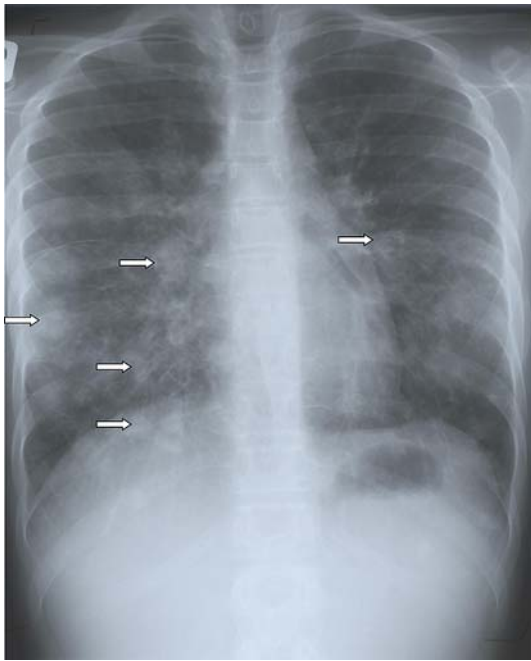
Chest X-ray of a patient with GBM. *Arrows* show a few of the lung metastases
